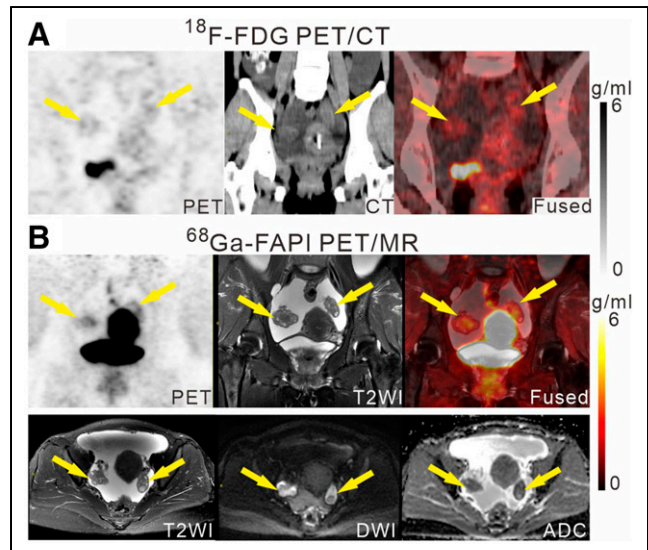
Comparison between ^{18}F -FDG PET/CT (A) and ^{68}Ga -FAPI PET/MR (B) for ovarian metastases in a 38-y-old woman (patient 1). Ovaries had slightly increased ^{18}F -FDG accumulation ($\text{SUV}_{\text{max}} = 2.6$) (A, arrows); it was difficult to determine whether this accumulation was physiologic uptake or metastases. On ^{68}Ga -FAPI PET/MRI, increased uptake ($\text{SUV}_{\text{max}} = 4.1$) was observed in enlarged ovaries with significant MR signal changes (heterogeneous signal on T2-weighted images [T2WI], high signal on DWI, and low signal on apparent diffusion coefficient [ADC]), which enhanced the confidence in making a diagnosis of metastases.
